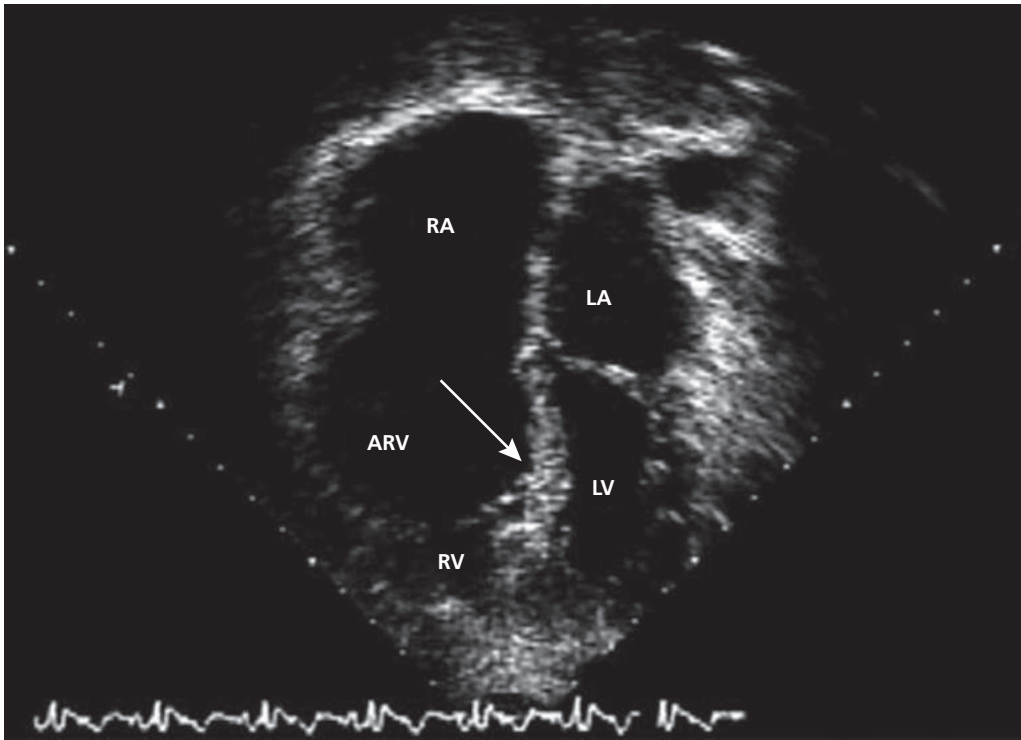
Ebstein's anomaly. Example of an echocardiogram (4-chamber view, apex down) of a patient with severe Ebstein's anomaly, showing a grossly displaced septal leaflet (arrow). The anterior leaflet is severely tethered and nearly immobile. The functional right ventricle (RV) is small.
